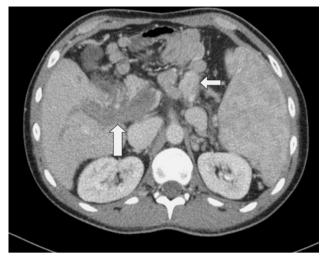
Contrast-enhanced CT revealed complete thrombosis of the intra- and extrahepatic PV (*large arrow*) and gastric varices (*small arrow*)
